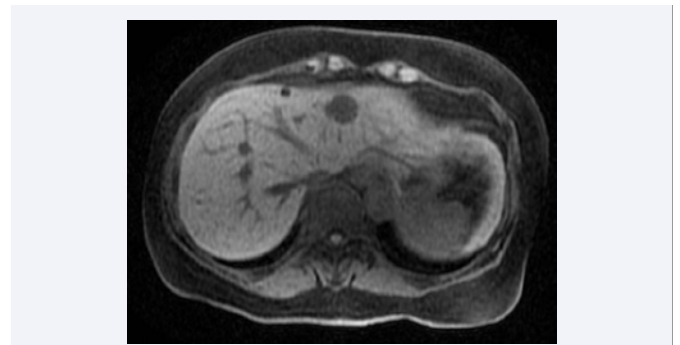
Axial MRI images of lesion in segment 2/4a.
